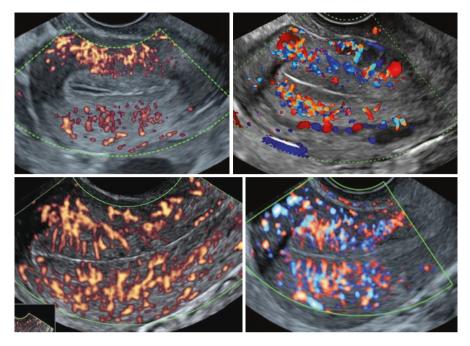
Doppler showing endometrial blood flow zone 1-4 from the upper left to clockwise
